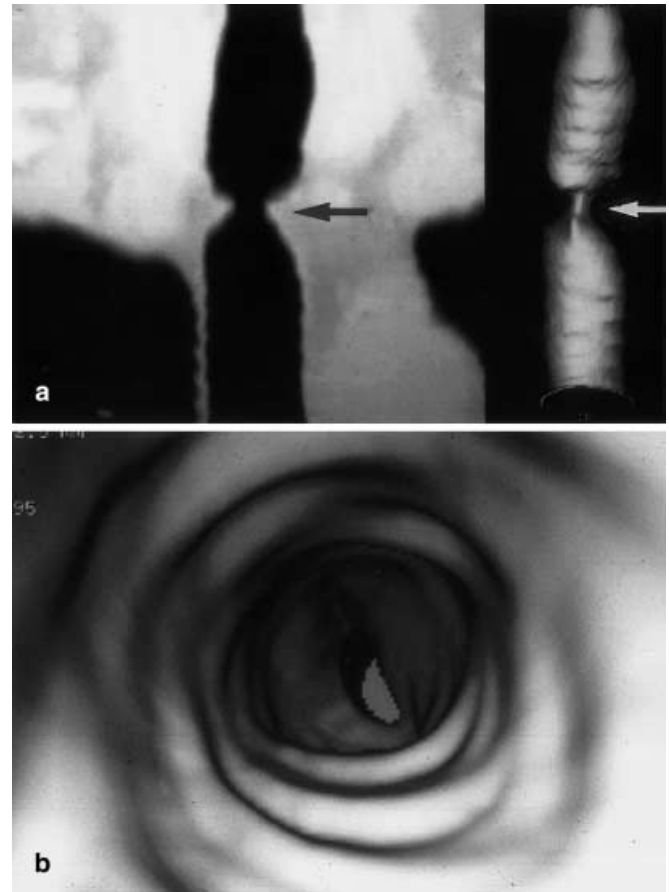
Tracheal stenosis occurred as a complication of tracheostomy. a Coronal oblique image of the trachea reformatted after helical CT acquisition showing the exact location and degree of the stenosis (*left*). The 3D surface shadowing display image (*right*) demonstrates the asymmetric aspect of the stenosis. b Descending virtual endoscopy view assesses the internal morphology of the stenosis
